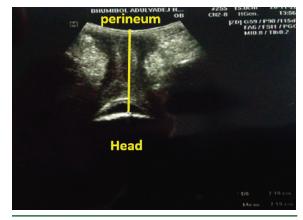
Transperineal ultrasound image of head perineal distance.
